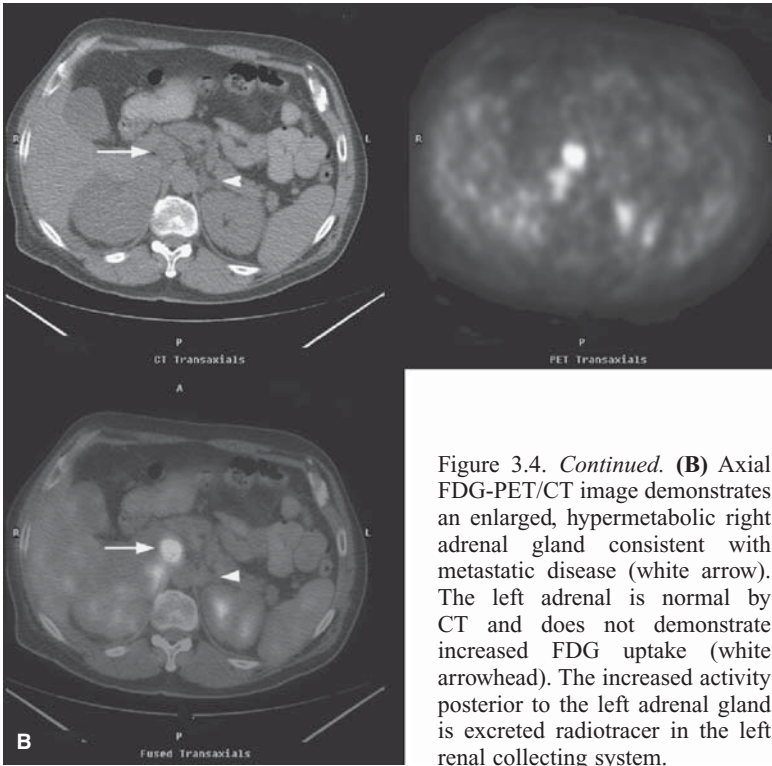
Left upper lobe NSCLC with distant metastases. (A) FDG-PET whole-body image demonstrating a left upper lobe malignancy (white arrow) with right adrenal metastasis (white arrowhead). Additional metastases are seen in the retroperitoneum.
